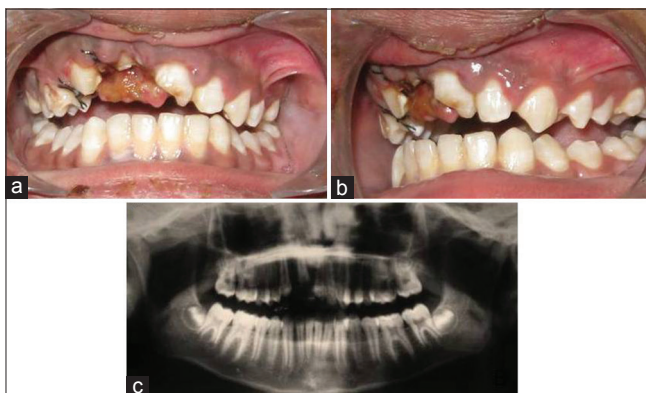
(a and b) Preoperative intraoral images of a 14-year-old boy 20 h after traumatic dental injuries, showing intrusive luxation in 13, 11, and 21 and uncomplicated crown fracture in 14, 11, and 21. (c) Orthopantomogram revealing extent of intrusion and avulsion of 12
